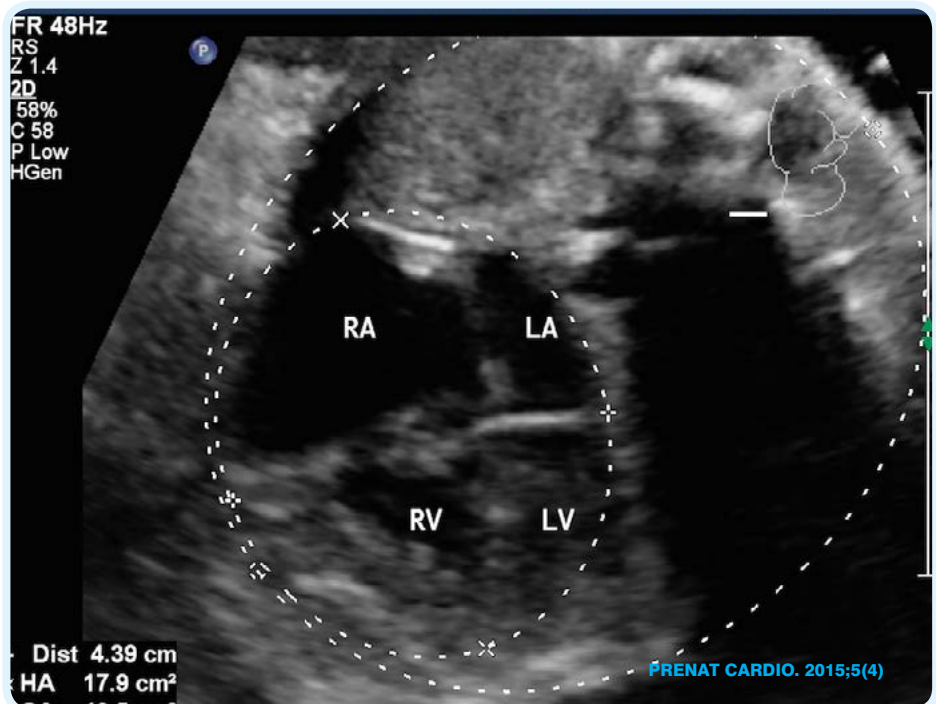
Prenatal echocardiogram.HA/CA
